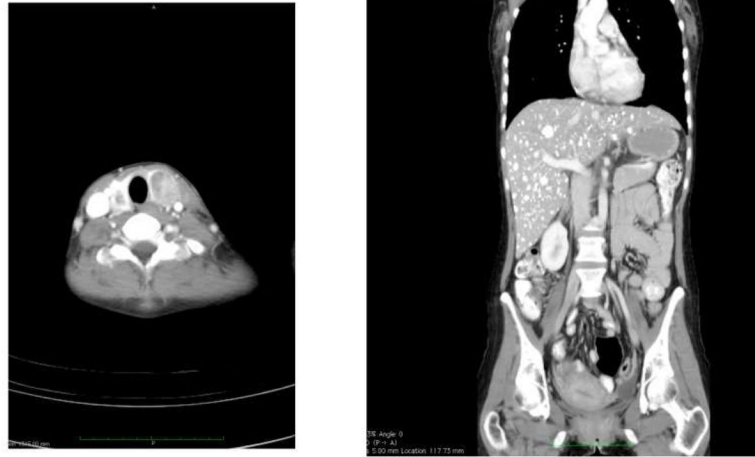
Metastatic medullary thyroid carcinoma (MTC) in MEN-2a patient who presented with bilateral neck nodules that were found to be primary MTC (left panel). Mass in left lobe was 4 cm and right was 2 cm. Coronal CT of the abdomen shows multiple diffuse bilateral liver metastases (right panel).
